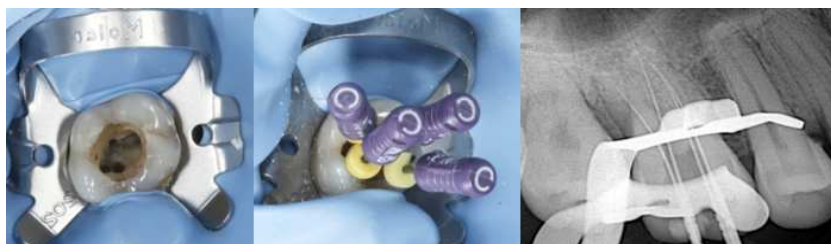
Root canal orifice of 16, working length measurement, radiographic of working length measurement.
